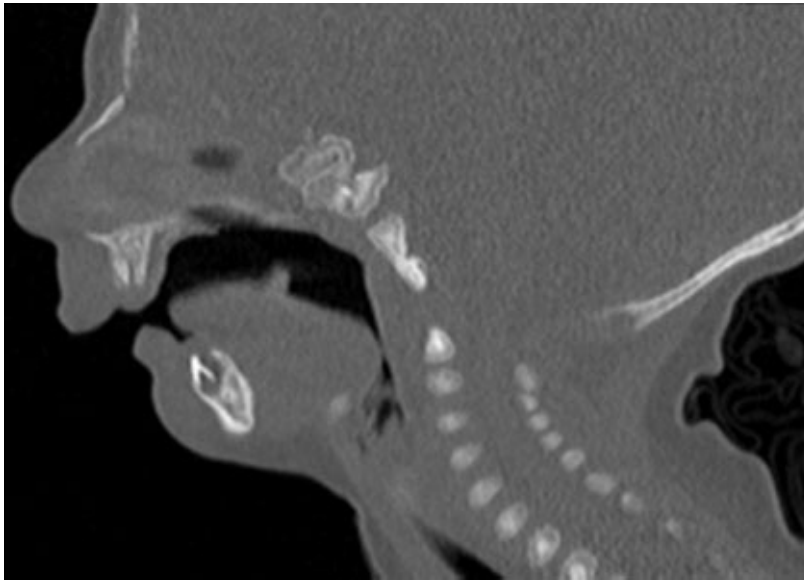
• CT scan showing mandibular micrognathia, retropositioning of the tongue, and narrow airway stripe.
